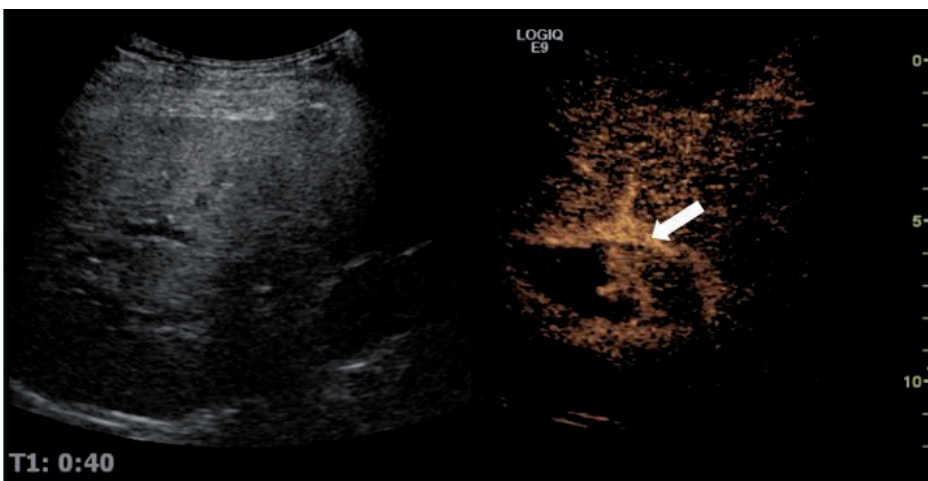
A contrast-enhanced ultrasound is carried out immediately after the thermal ablation. In conventional ultrasound, the necrotic cavity does not show up very clearly. Following injection of contrast medium, there is a non-opacified area which remains from the early phase onwards for the whole duration of the ultrasound examination.
